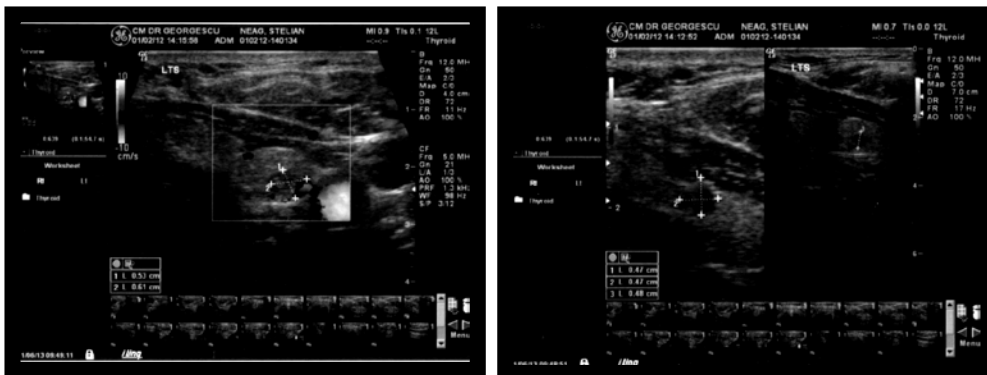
Parathyroid adenoma: ultrasound features
